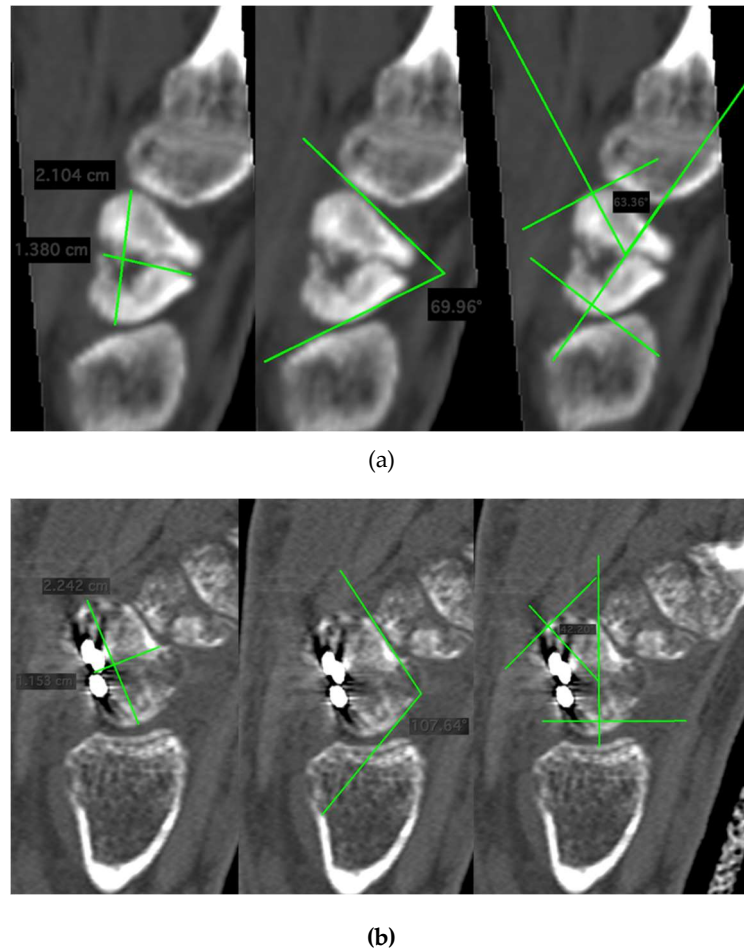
Pre-operative (a), post-operative (b) CT sagittal images on scaphoid showing improvement of H:L ratio from 0.65 to 0.51, DCA from 69.9° to 107.6° and LISA from 63.3° to 42.2°.
